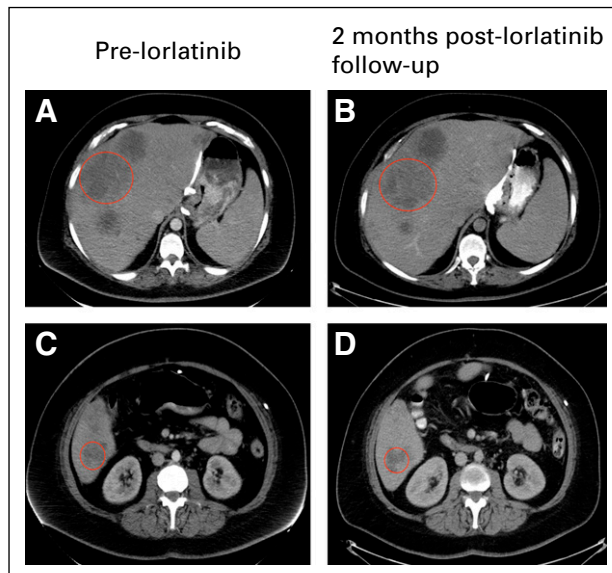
Computed tomography imaging of hepatic metastasis before and after lorlatinib. In row 1, the circled hepatic lesion after disease progression on fluorouracil, folic acid, oxaliplatin, and irinotecan (A) before lorlatinib was stable in size (B) 2 months after lorlatinib treatment. Similarly, row 2 shows a different metastatic hepatic lesion (C) before lorlatinib with stable disease (D) after 2 months of lorlatinib. The patient currently continues to be treated with lorlatinib.
